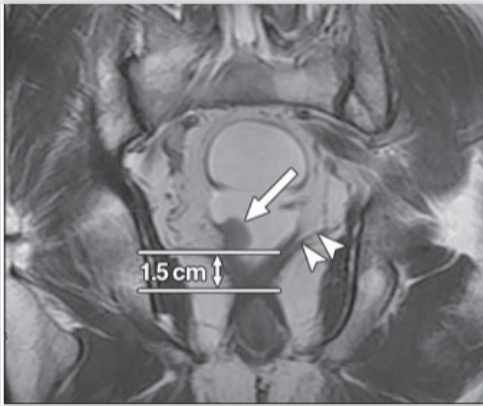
58-year-old man with T2 moderately differentiated rectal adenocarcinoma (arrow). Coronal T2-weighted MR image shows distance from lower margin of rectal tumor to point where levator ani muscle (arrowheads) attaches to rectum is 1.5 cm (double arrow). Patient underwent internal sphincter resection with prolapsing technique to save external sphincter and anus.
